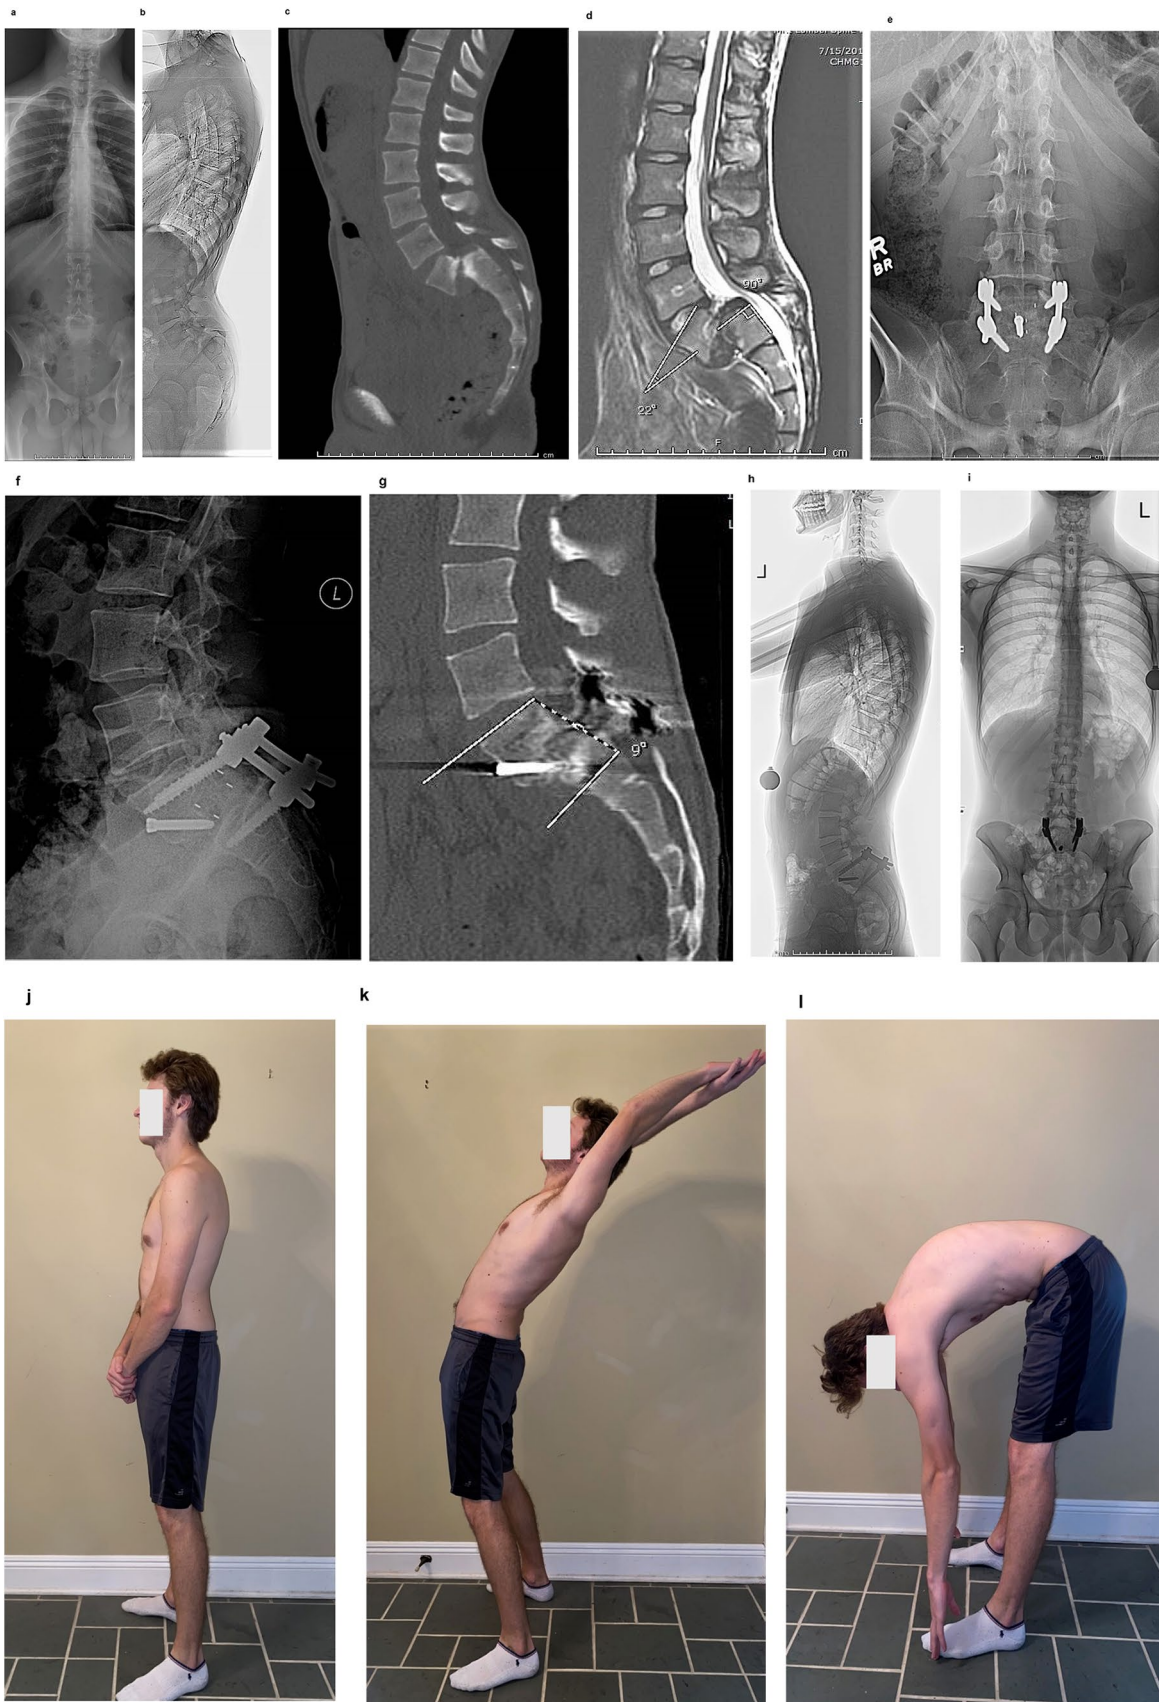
Preoperative and postoperative imaging and pictures for patient No 2. Preoperative full spine standing AP (a) and lateral (b) radiographs showing grade 4 HGS and 22° slip angle; preoperative sagittal CT scan (c) with sclerotic changes in both endplates as well as dystrophic sacral dome, sagittal MRI T2-sequence image (d) demonstrating normal signals in all lumbar discs except for “bilobed” L5/S1 disc as well as spinal canal narrowing at lumbosacral junction; and postoperative AP (e) and lateral (f) plain radiographs and sagittal CT scan cut (g). The free screw was inserted to block loss of position of the interbody cage during turning from anterior to posterior. Postoperative standing AP (h) and lateral (i) radiographs as well as pictures of range of motion (j–l) 6 years after surgery demonstrate the success of the surgery
